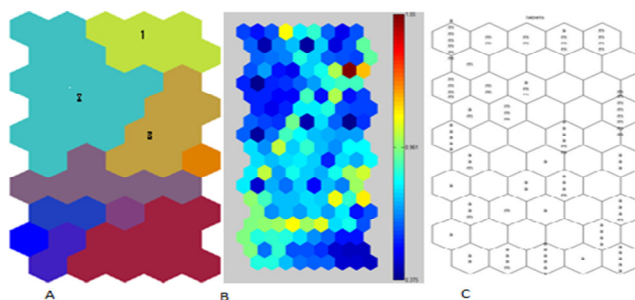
SOM clustering of ultrasound data A) Clusters (colour coded). B) SOM U-matrix (the distance between the neighbour nodes in the SOM lattice is represented by a colour bar that appears on the right side of the figure, the distances range from dark blue (small distance) to dark red (large distance). C) The distribution of the benign (a) and malignant (m) cases over the SOM lattice.
